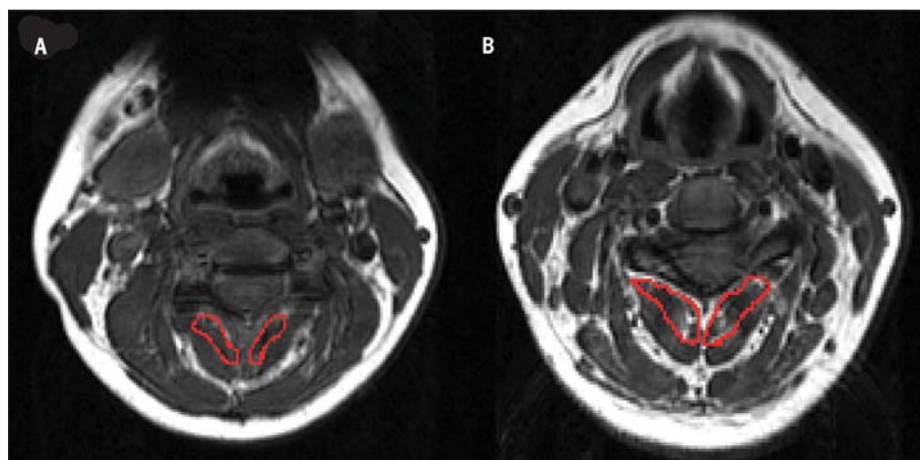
Bilateral axial magnetic resonance images of the segmental cervical multifidus muscles (outlined in red) at C3 (healthy control [A] compared to a subject with whiplash-associated disorder [WAD] [B]). Reproduced from Elliott J, Jull G, Noteboom JT, Darnell R, Galloway G, Gibbon WW. Fatty infiltration in the cervical extensor muscles in persistent whiplash-associated disorders: a magnetic resonance imaging analysis. *Spine*. 2006;31:E847-855. Reprinted with permission from Lippincott, Williams & Wilkins.
